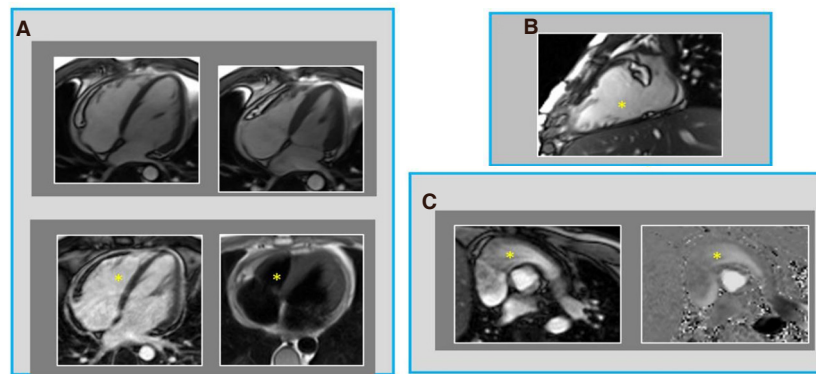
Representative examples of right ventricular assessment via cardiac magnetic resonance (CMR). A: Top: Functional assessment via steady state free precession cine-CMR (left = end-diastole, right = end-systole). Bottom: Myocardial tissue characterization via late gadolinium enhancement CMR (for infarction/fibrosis) and T1-weighted spin echo-CMR (for fat infiltration); B: Dedicated right ventricular functional assessment via cine-CMR; C: Flow assessment via phase-velocity encoded CMR (left = magnitude data, right = phase-encoded data). Asterisk corresponds to the right ventricle in each image
